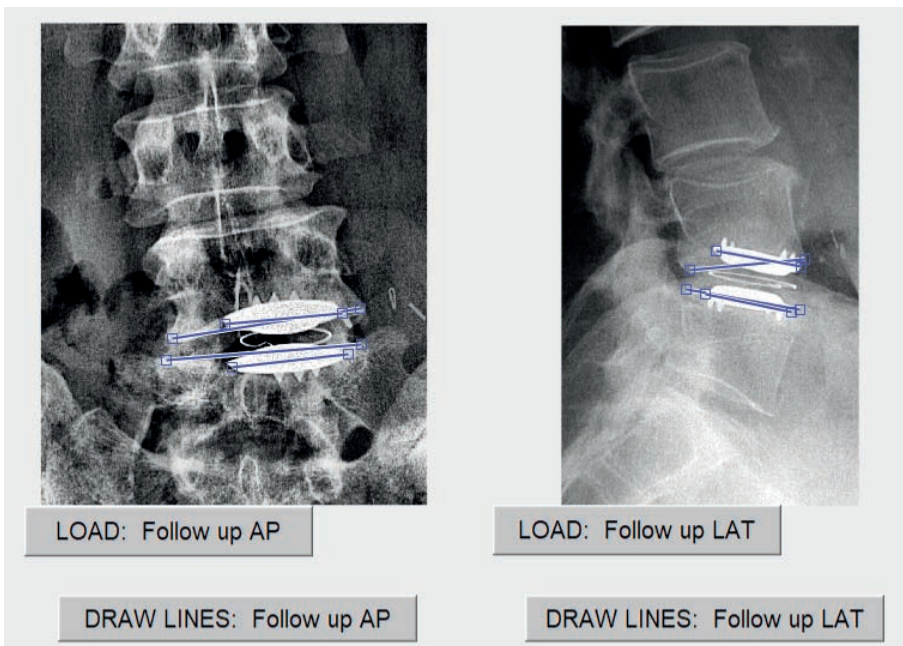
Angular rotation between the vertebral- and prosthetic endplate on an AP and LAT radiograph.
